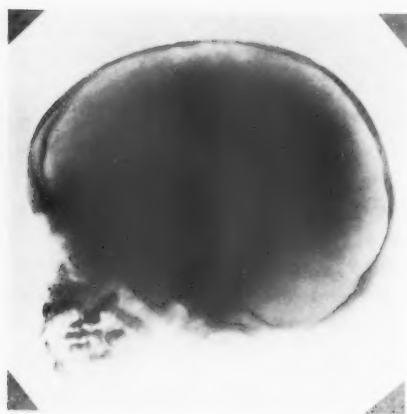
Case 1. X-ray appearances of skull, May 29, 1931.
